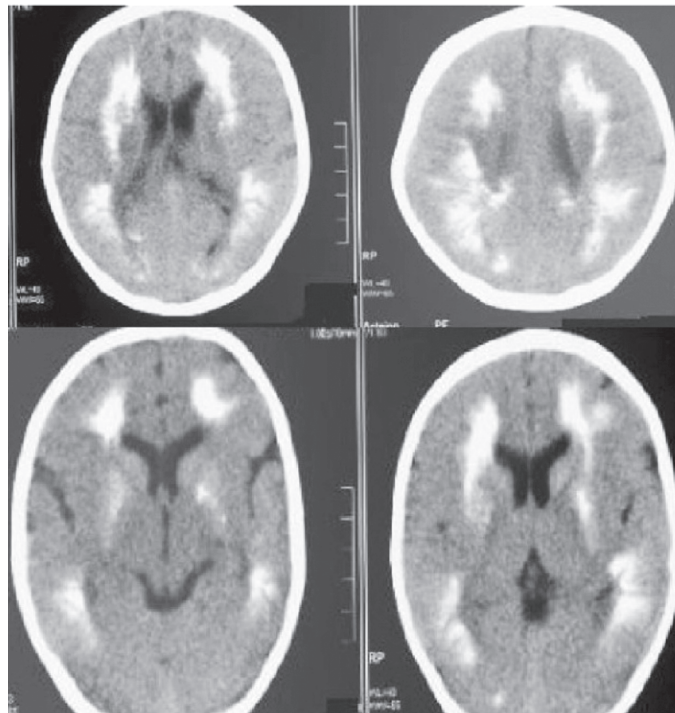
CT sections of the brain showing extensive confluent calcifications in the white matter (subcortical to periventricular) in a symmetric distribution. Globus pallidus calcification is also present.
